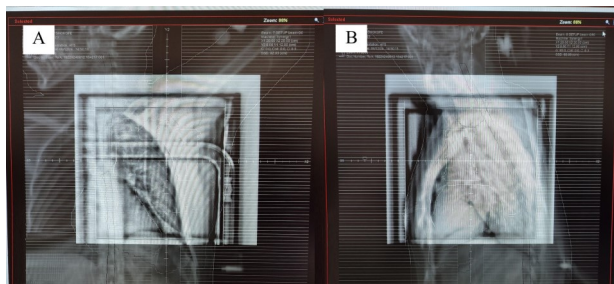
2D image registration of DRR (Digitally Reconstructed Radiograph) and EPID (Electronic Portal Imaging Device) images by mosaic system indicating matching lateral DRR and EPID images (A), and matching AP DRR and EPID images (B).
